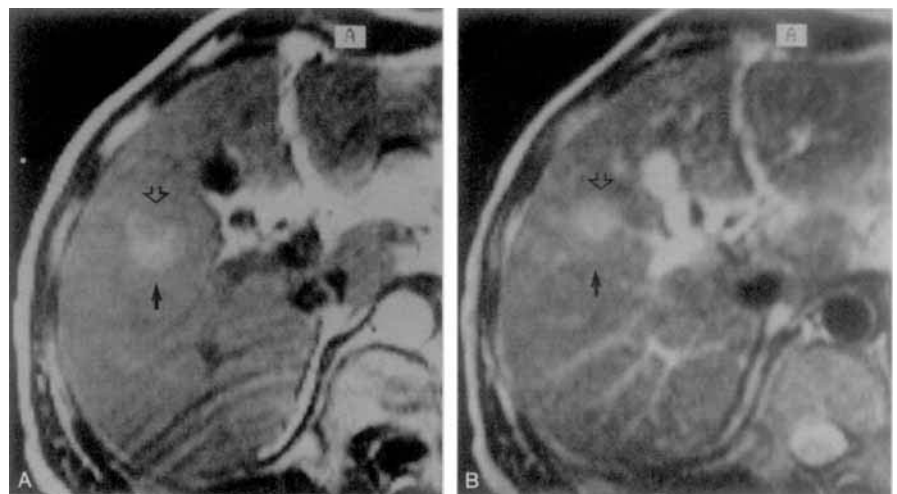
The precontrast T1-weighted image shows a hyperintense nodule (arrow) with a central isointense component (arrowhead) (A). The precontrast T2-weighted image shows a central hyperintense component (arrowhead) within a peripheral isointense area (arrow) (B).
